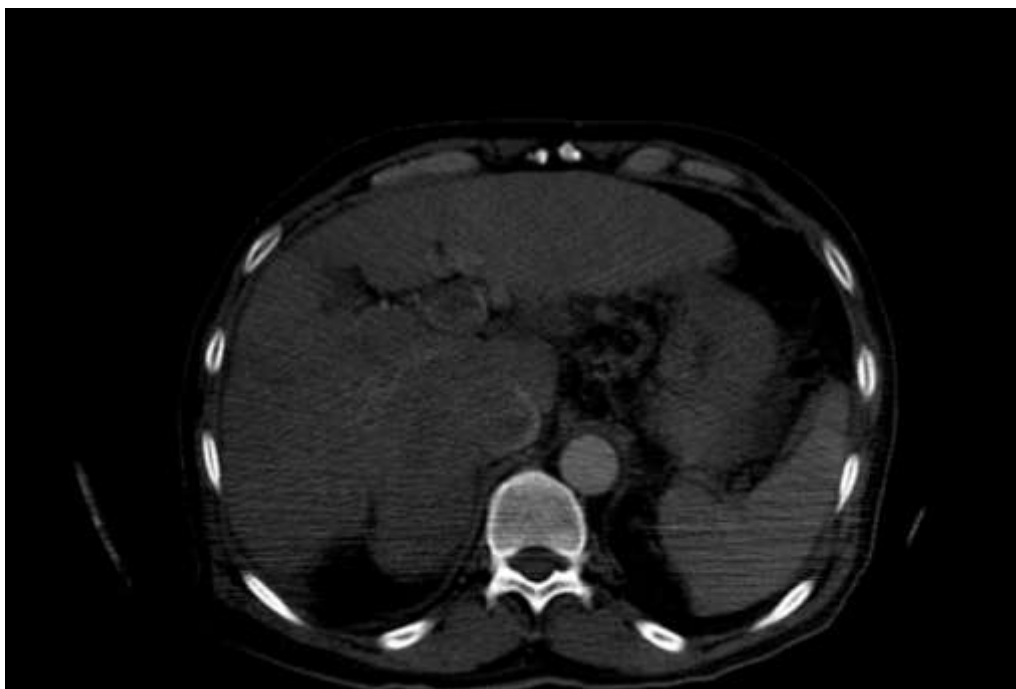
Axial contrast-enhanced CT image demonstrating tumor thrombus within the inferior vena cava.
